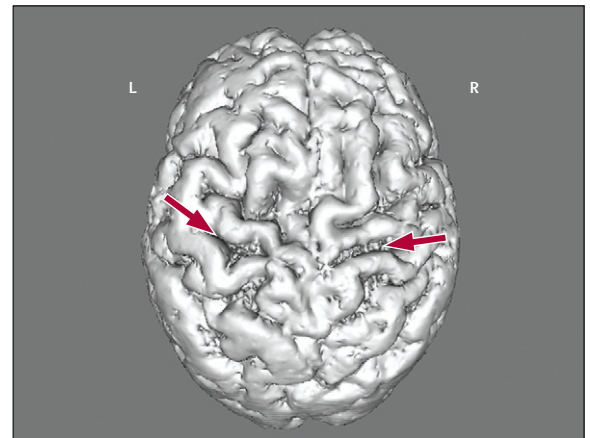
3-Dimensional MRI of a brain of a patient with primary lateral sclerosis, as shown from above
